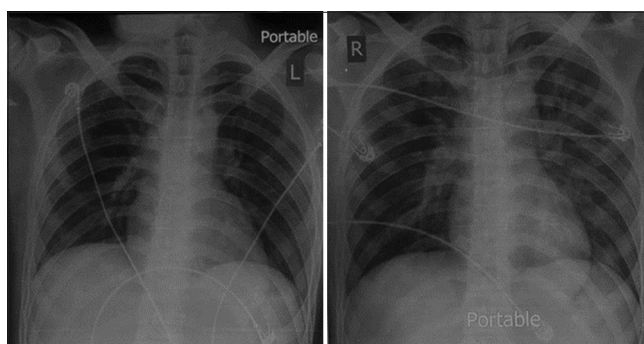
Chest radiography: on admission (on the left): normal and on the 5th day of admission (on the right): With diffuse fibrotic change and reticulonodular opacities in bilateral lungs
